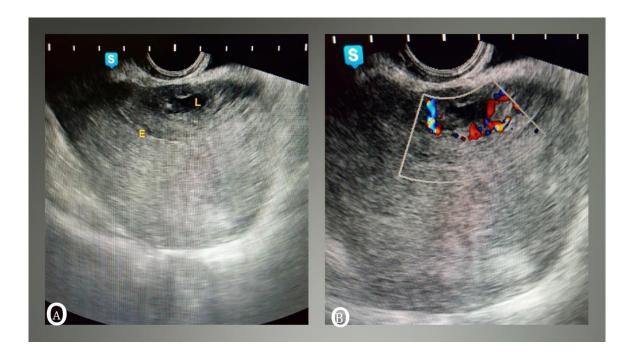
(A): Transvaginal ultrasound, E: endometrium. L: lesion; a focal heterogeneous area of anterior myometrium 3x2 cm. (B): Colour Doppler shows increased flow.
